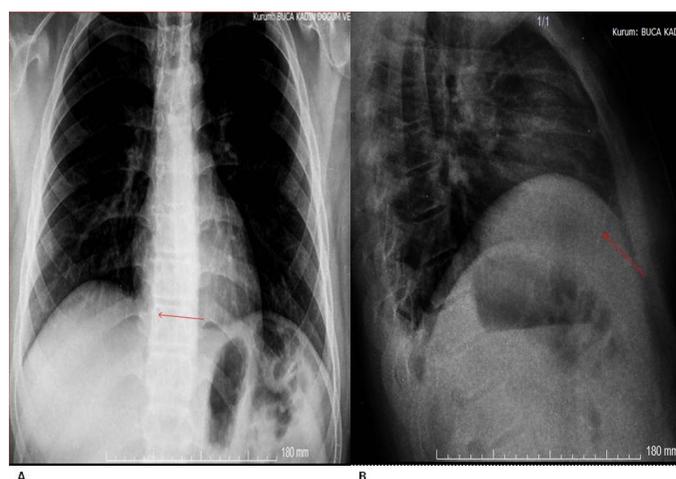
A high-density foreign body superposed on the anterior mediastinum in the area marked with the arrow in the posterior-anterior (A) and lateral (B) chest X-ray images
